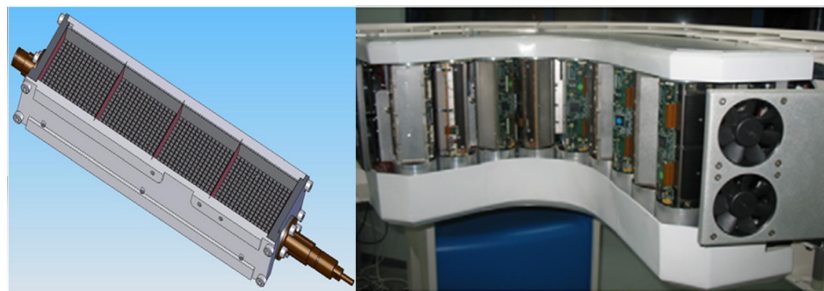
D-SPECT detection system. Details of one detector (on the left) and the whole camera (on the right). It is possible to observe that each detector is mounted vertically, and that the camera has a curved configuration. Image adapted¹⁵.
